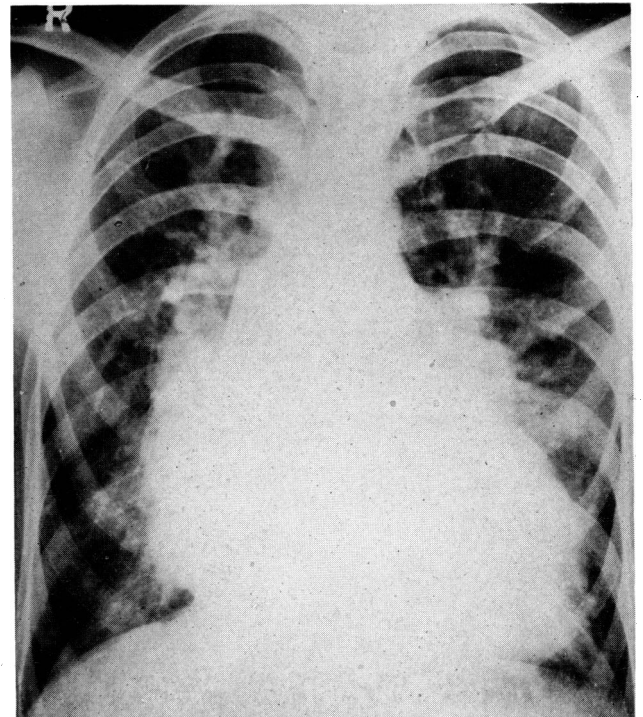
X-ray appearances in V.S.D., showing pulmonary plethora and left ventricular enlargement.
